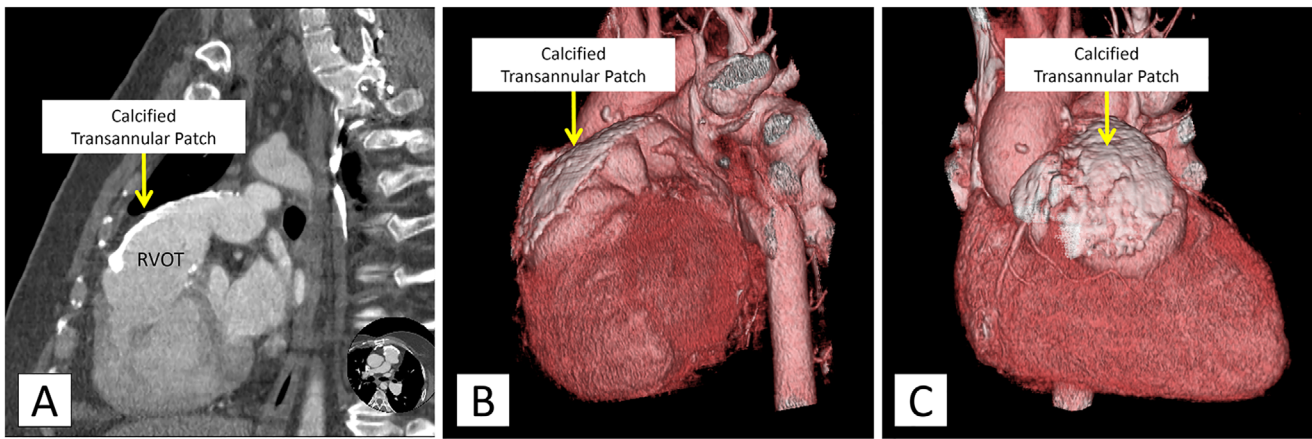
CT imaging of TOF repair 2D (Panel A) and 3D (Panels B and C) CT imaging shows a calcified transannular patch in an adult patient post-childhood TOF repair. RV, right ventricle.
